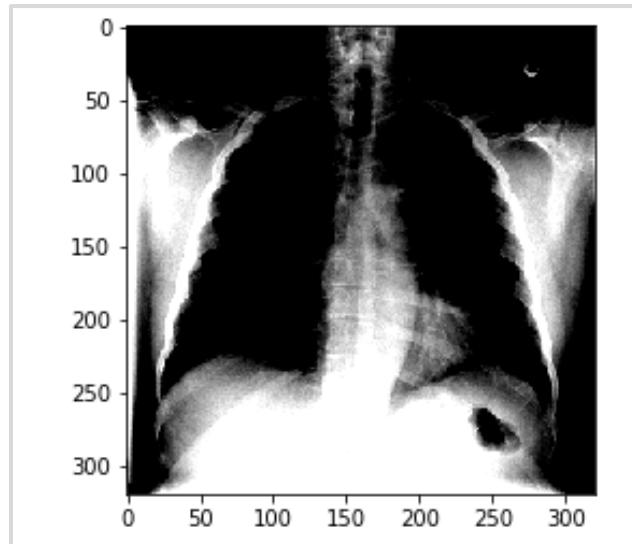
processed chest x-ray image.
